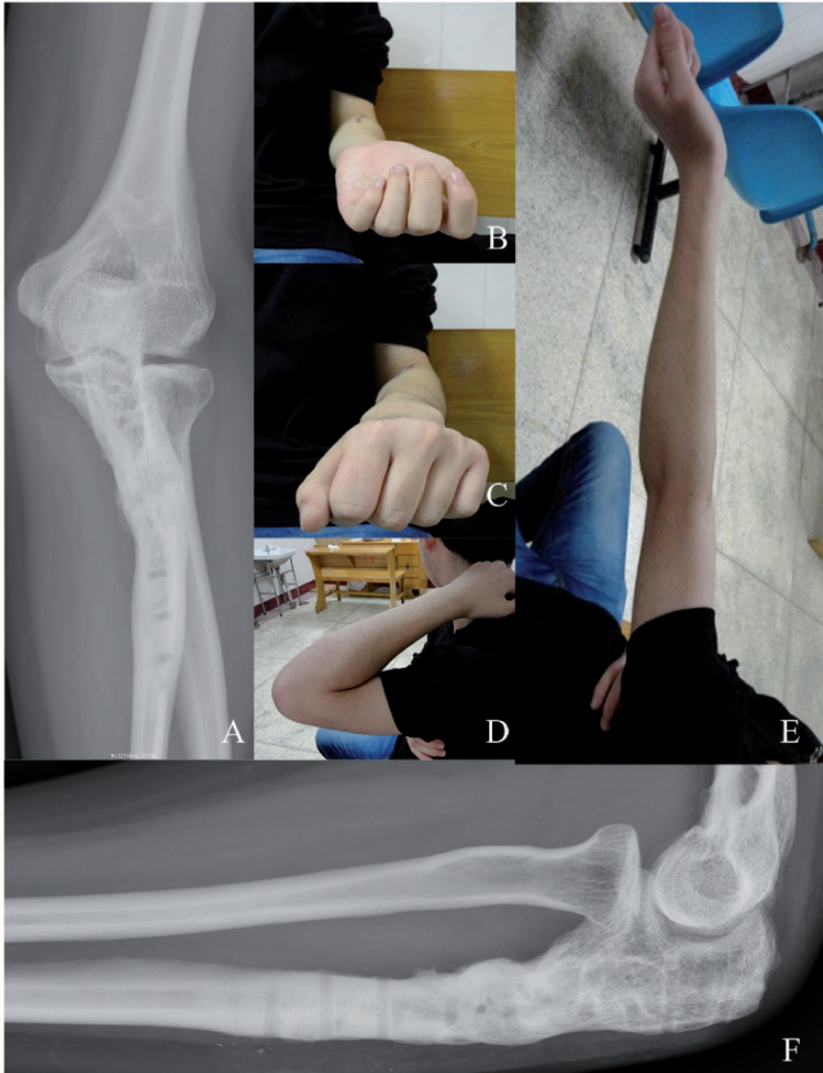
The radiographic (a, f) and functional (b to e) outcomes at the 7-year follow-up were both evaluated. A stable reduction and full range of elbow motion was found.
